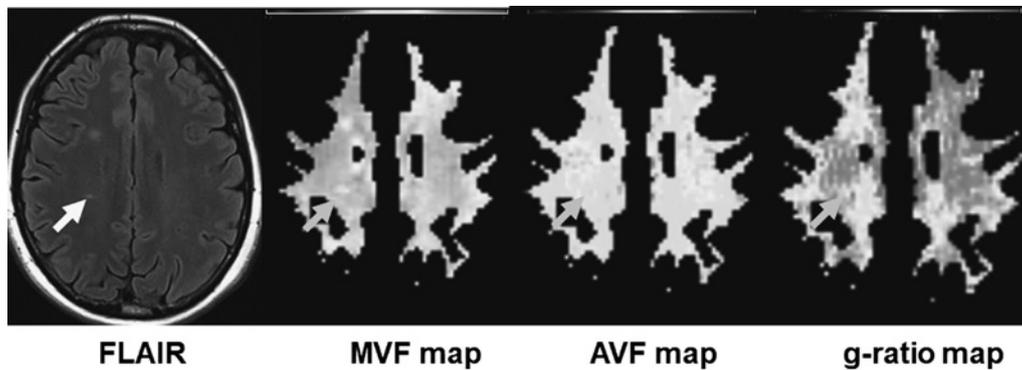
Axial FLAIR image, corresponding MVF map, AVF map, and g-ratio map of a patient with multiple sclerosis. The degree of the damage in the demyelinated lesion was different on MVF, AVF, and g-ratio maps. FLAIR, fluid-attenuated inversion-recovery; MVF, myelin volume fraction; AVF, axon volume fraction
